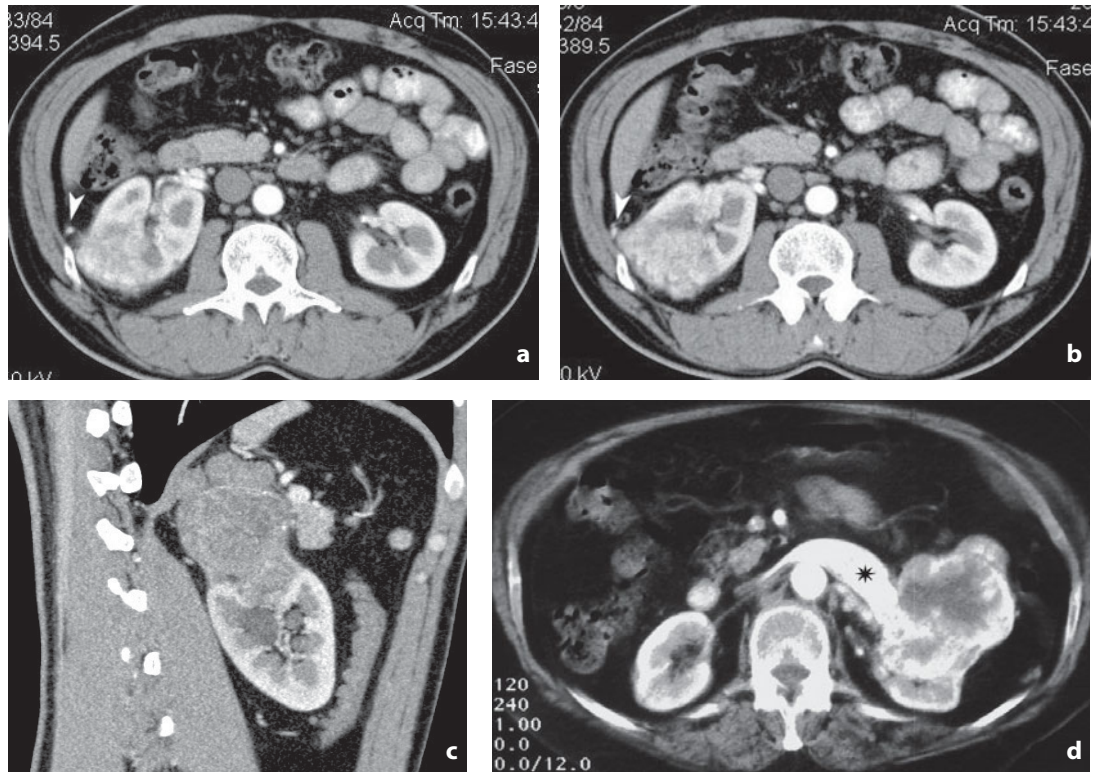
Computed tomography. Renal cell carcinoma. a, b Stage T3a neoplasm of the upper third of the right kidney: small solid lesion in the perirenal fat (*arrowhead*). c Different case, stage T3a. Solid mass in the upper renal pole of left kidney, with solid nodules in the perirenal fat indicating extracapsular extension. d Solid mass, stage T3b. Corticomedullary phase of dynamic study. The image shows a parenchymal neoplasm of the left anterior renal lip invading the renal vein (*asterisk*)
